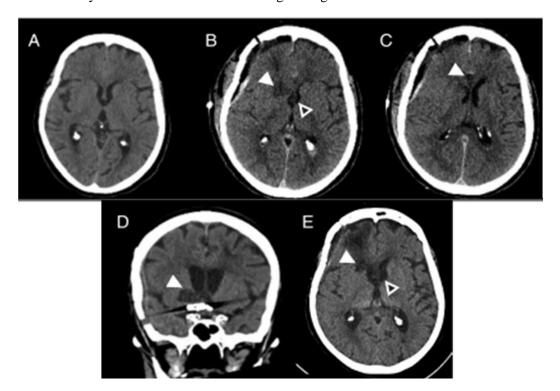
Baseline axial CT (A) and immediate post-clipping axial CT scans (B and C) demonstrating right caudate/basal forebrain infarction (white arrowhead) with forniceal (hollow arrowhead) and genu of corpus callosum infarction (white arrowhead). Follow-up coronal (D) and axial CT scans (E) demonstrating right basal forebrain infarct extending into the right septal region (white arrowhead), right caudate and internal capsule infarct (white arrowhead) and forniceal infarct (hollow arrowhead).
